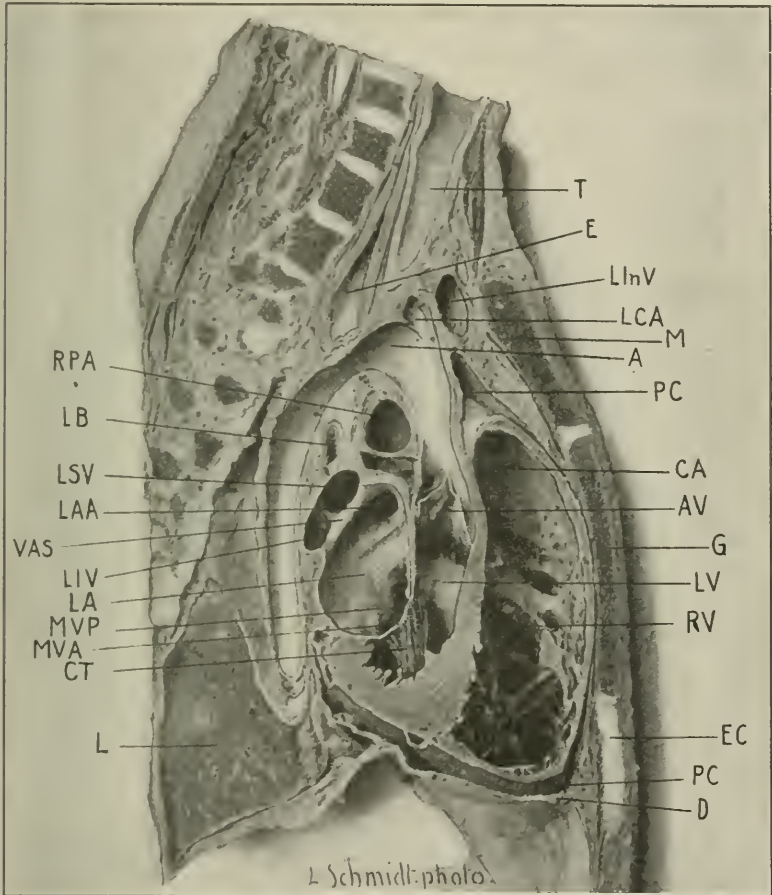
Median anteroposterior section through the thorax. *L*, lung; *CT*, chordae tendineae; *MVA*, mitral valve, anterior leaflet; *MVP*, mitral valve, posterior leaflet; *LA*, left auricle; *LIV*, left inferior pulmonary vein; *VAS*, veno-appendicular septum; *LAA*, left auricular appendix; *LSV*, left superior pulmonary vein; *LB*, left bronchus; *RPA*, right pulmonary artery; *T*, trachea; *E*, oesophagus; *LInV*, left innominate vein; *LCA*, left common carotid artery; *M*, manubrium; *A*, aorta; *PC*, pericardial chamber; *CA*, conus arteriosus; *AV*, aortic valve leaflets; *G*, gladiolus; *LV*, left ventricle; *RV*, right ventricle; *EC*, ensiform cartilage; *D*, diaphragm.
